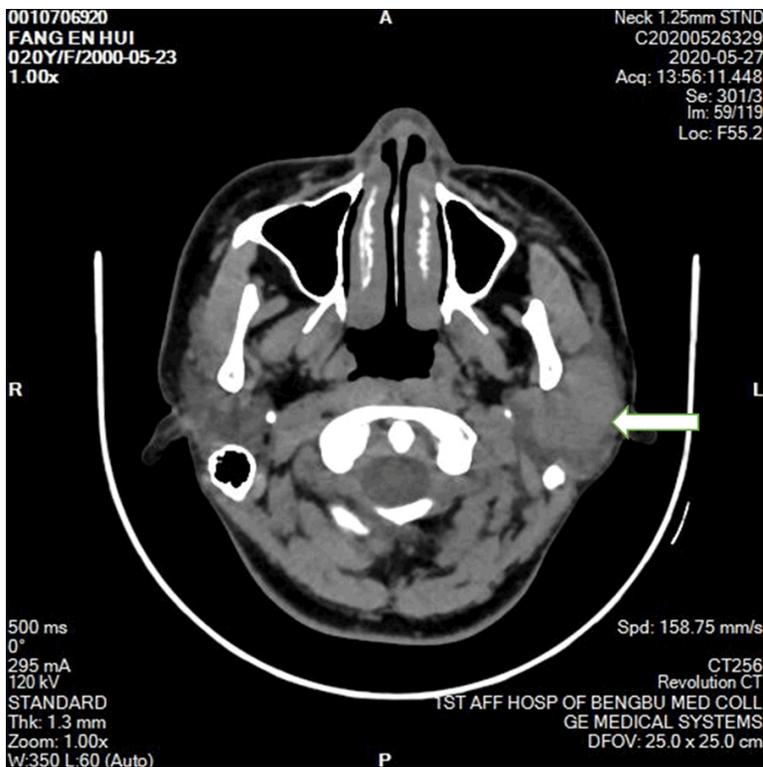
CT showed that a round isodensity mass could be seen in the left parotid gland, with clear boundary and uniform density.
